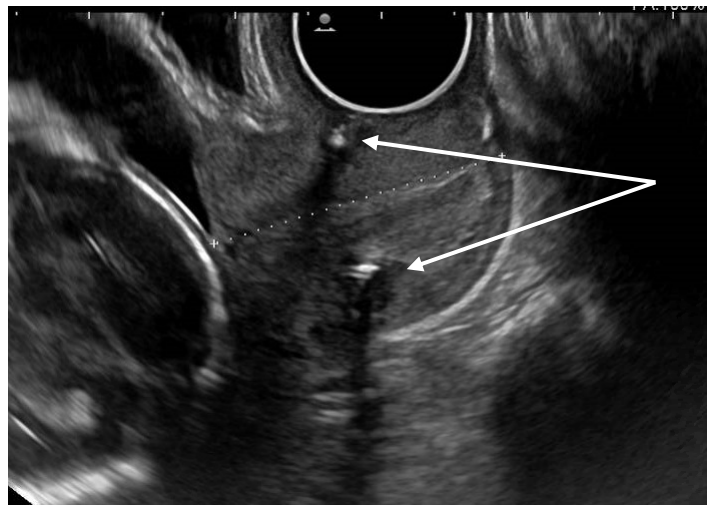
Transvaginal ultrasound of transvaginal cerclage at mid-length of the cervix. The McDonald cerclage is shown as an echogenic structure.
